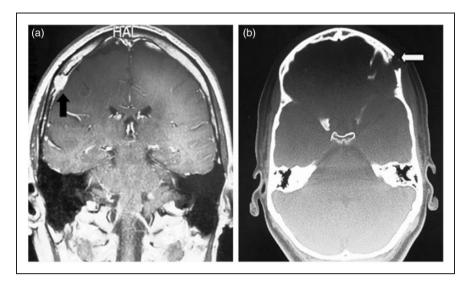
(a: Case 1) Post-gadolinium DTPA T-weighted coronal magnetic resonance imaging (MRI) demonstrating an eosinophilic granuloma (black arrow). (b: Case 2) Bone window of an axial computed tomography (CT) scan showing a lytic lesion—eosinophilic granuloma (white arrow).
